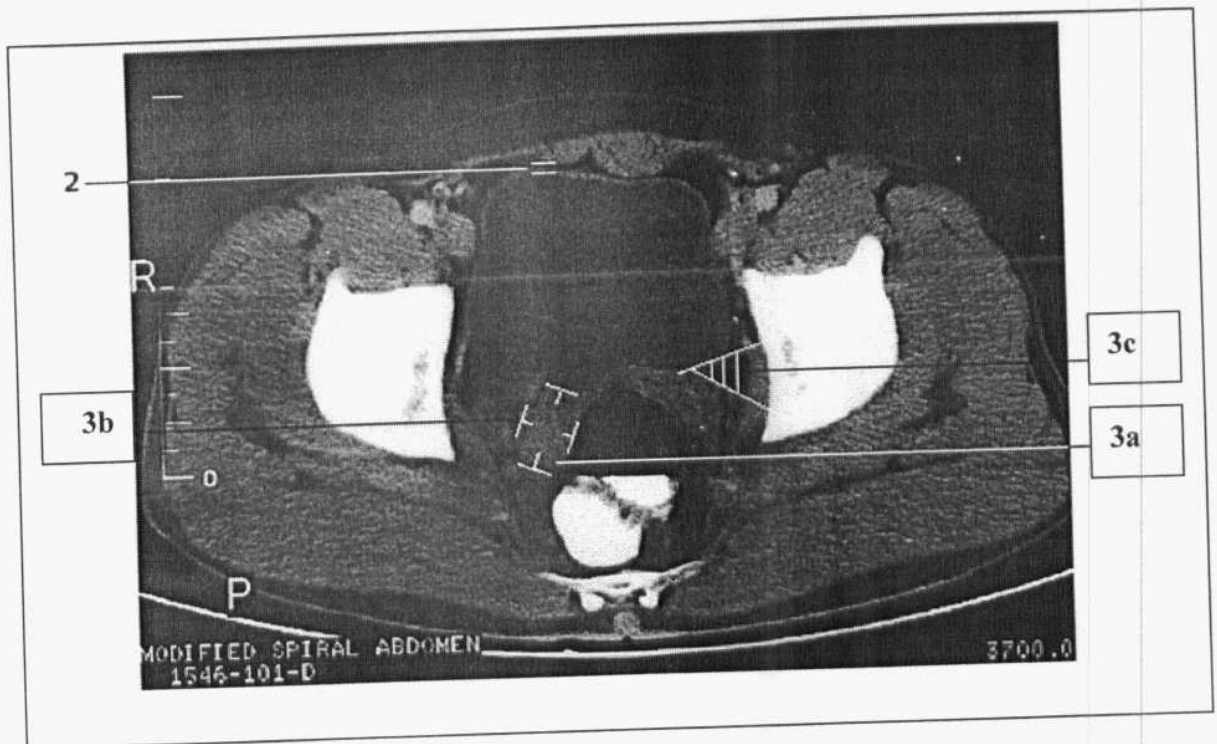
Normal axial CT anatomy of male pelvis
